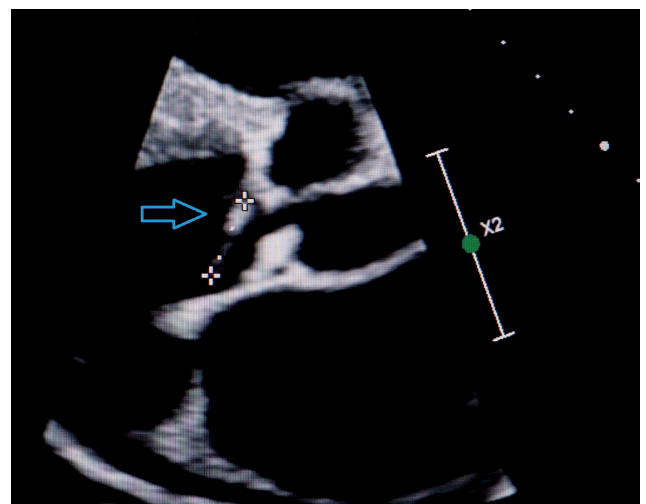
Echocardiography showing vegetation (blue arrow) on the aortic valve
